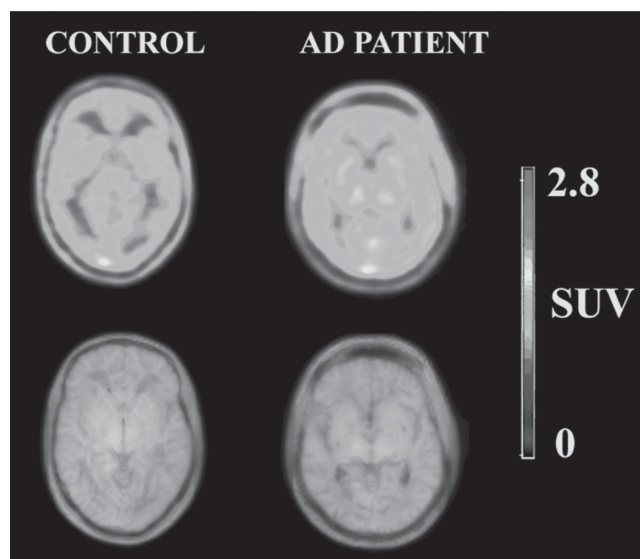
Transaxial magnetic resonance–coregistered positron emission tomography (PET) summation images recorded from 20 to 90 min after intravenous injection of [^{11}C]ST1859 into 1 control subject (HV 1) (left) and 1 AD patient (patient 9) (right). The lower row shows the same PET images with the transparency of the superimposed magnetic resonance scan set to 50%. The radioactivity concentration is normalized for injected radioactivity per body weight and expressed as the SUV. *Source:* p. 829 from Tozuka *et al.* [45]. (See color insert.)
